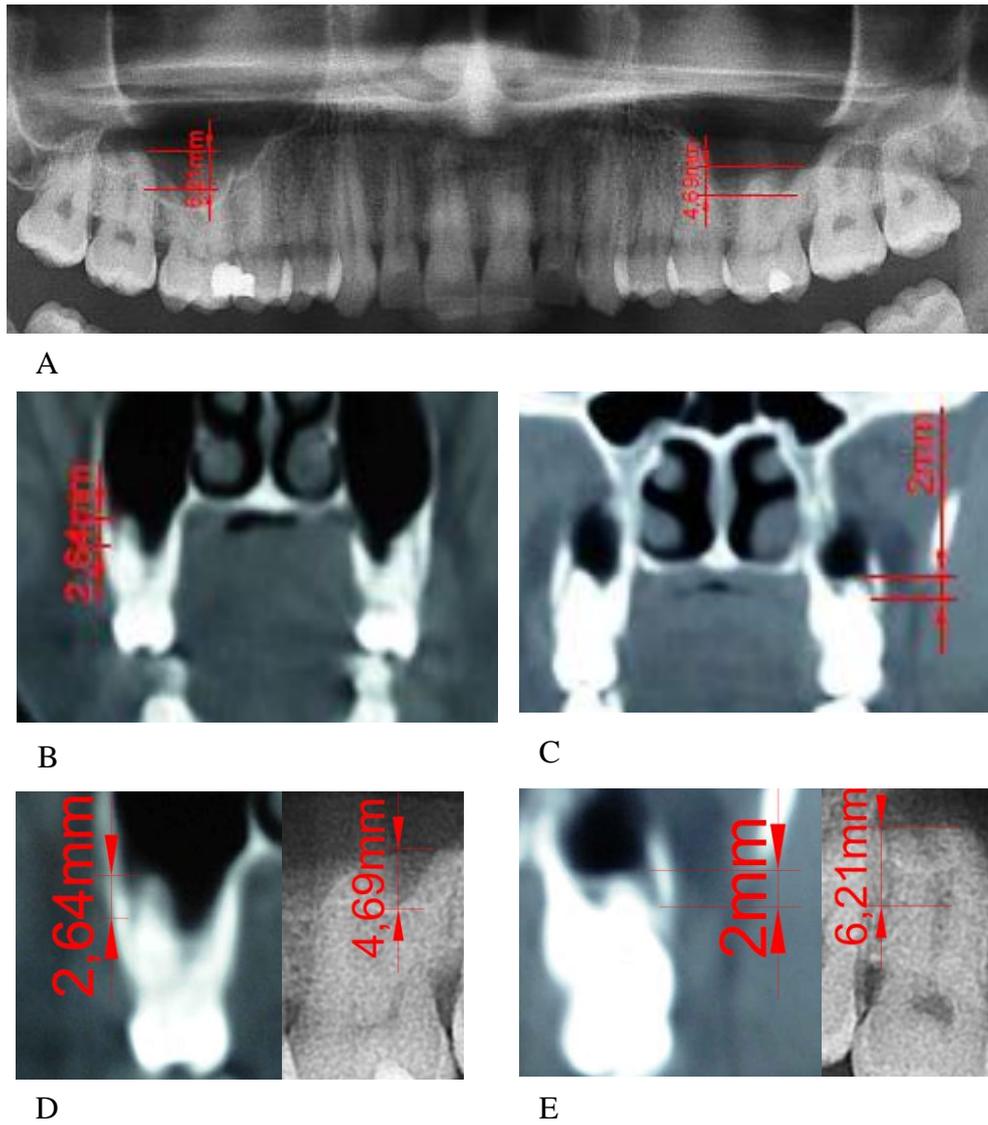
Images for a patient with bilateral maxillary posterior teeth roots projection in the maxillary sinus (upper right 2<sup>nd</sup> molar and left 1<sup>st</sup> molar). Measured values of the root-projection lengths in OPG and root-protrusion lengths in the CT images are shown. (A) OPG radiograph. (B and C) CT image. Higher zooming view for the requested teeth from above both images for right (D) and left (E) were shown.
